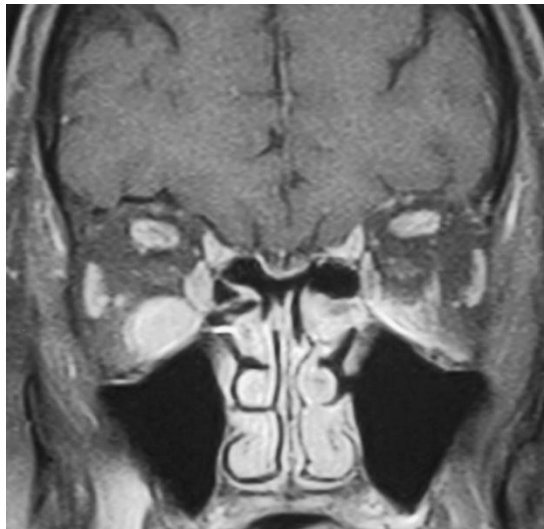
MRI coronal section demonstrating enlarged right inferior rectus muscle.
